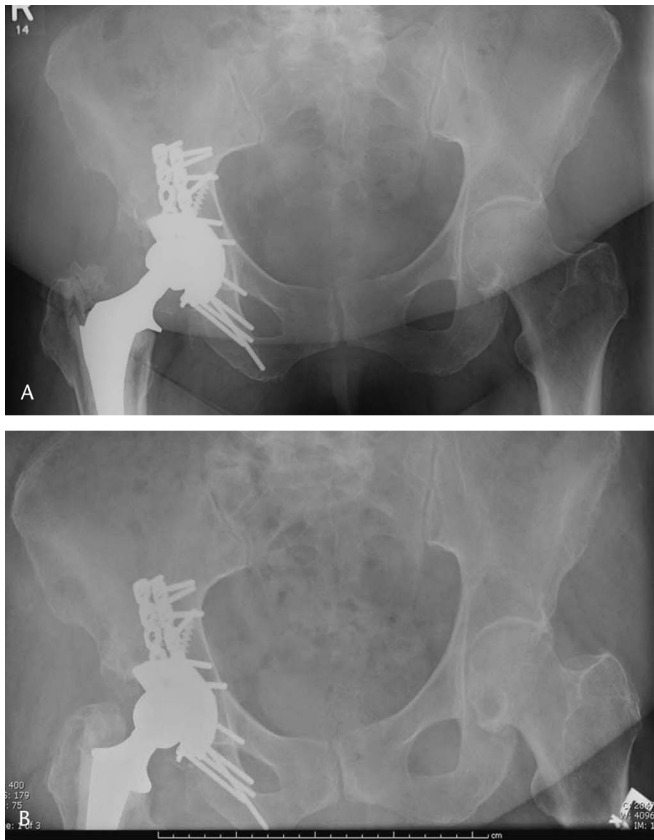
A, Anteroposterior radiograph showing immediate post operative fixation. B, Anteroposterior radiograph showing late post-operative fixation.
